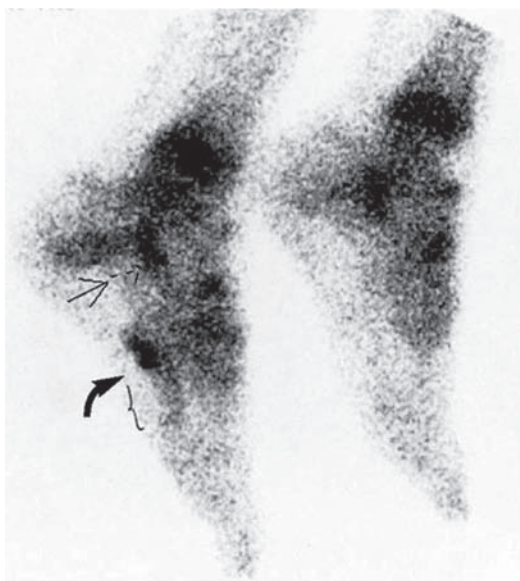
Bone scintigraphy can occasionally be valuable. The arrow shows an area with increased uptake of radioactive isotopes, a sign of a stress fracture.
